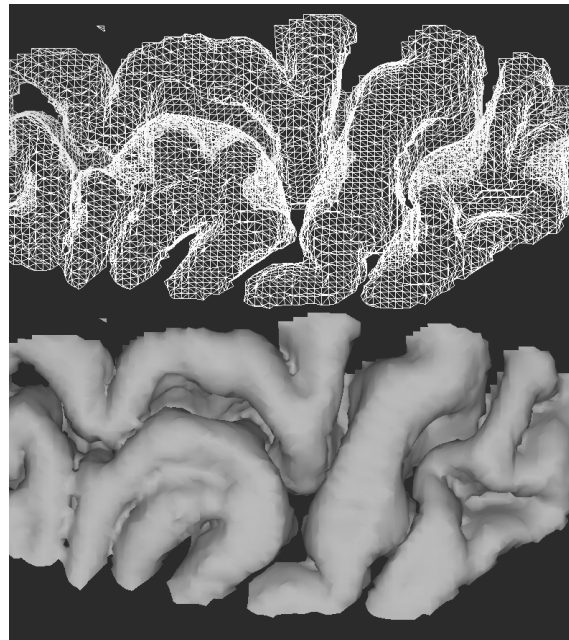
Triangulated (top) and shaded (bottom) portion of the brain from MRI, created with the marching cubes algorithm.*
